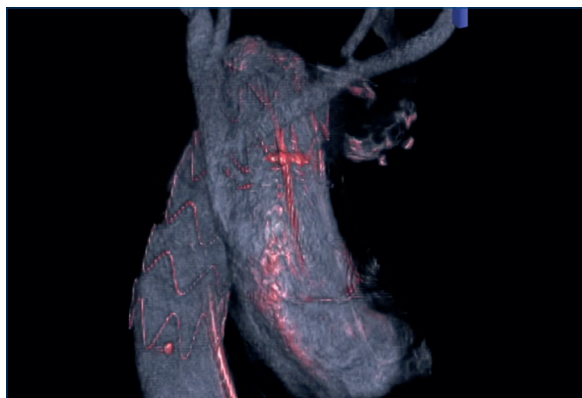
• A contrast-enhanced cone-beam computed tomography is performed at the end of the procedure to check target vessel patency, stent-graft integrity and absence of endoleaks (3D volume rendering and maximum intensity projection reconstructions of total debranching TEVAR for Kommerel diverticulum in right aortic arch repair).
